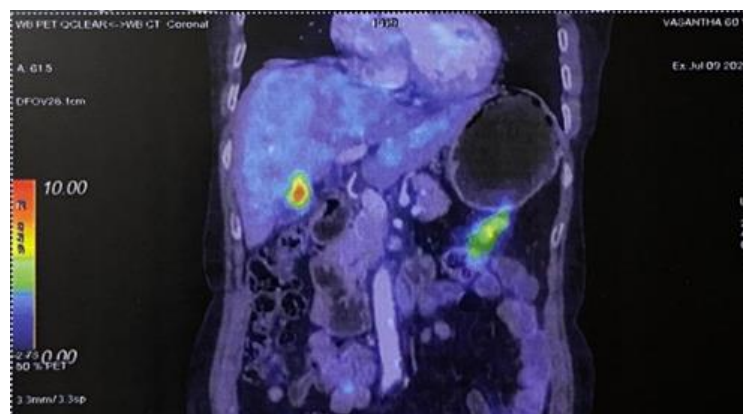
Hyper metabolic mass in the gall bladder suggestive of carcinoma on PET CT. SUV max 8.7. lesion appears adherent to the gall bladder fossa of liver suggestive of an early invasion.
